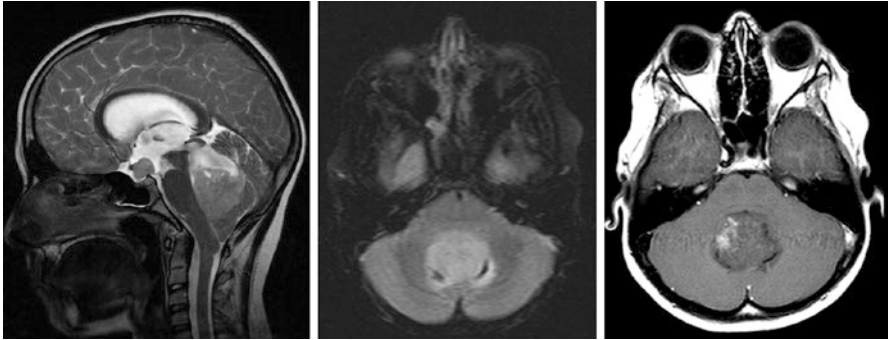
Medulloblastoma. Sagittal T2, axial FLAIR and axial T1 post-GAD images of the brain are demonstrating an intraventricular heterogeneous mass, with irregular enhancing with gadolinium
